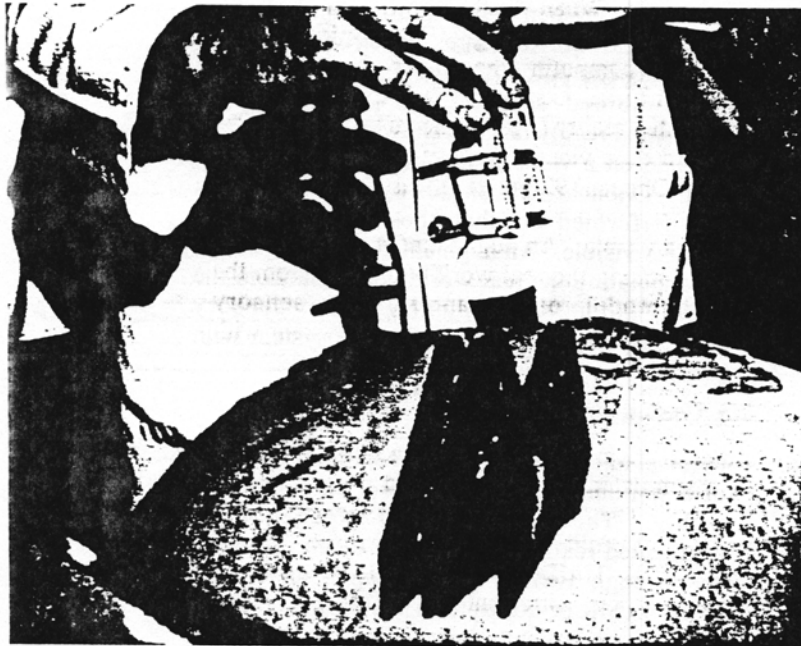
Ultrasound visualization in augmented reality
